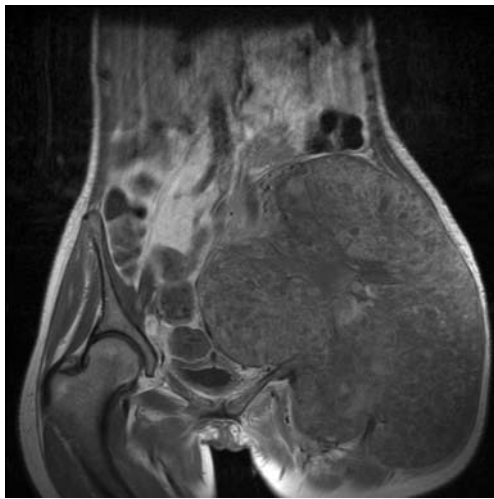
Magnetic resonance image of the pelvis on admission showing a large ABC of the left ilium
